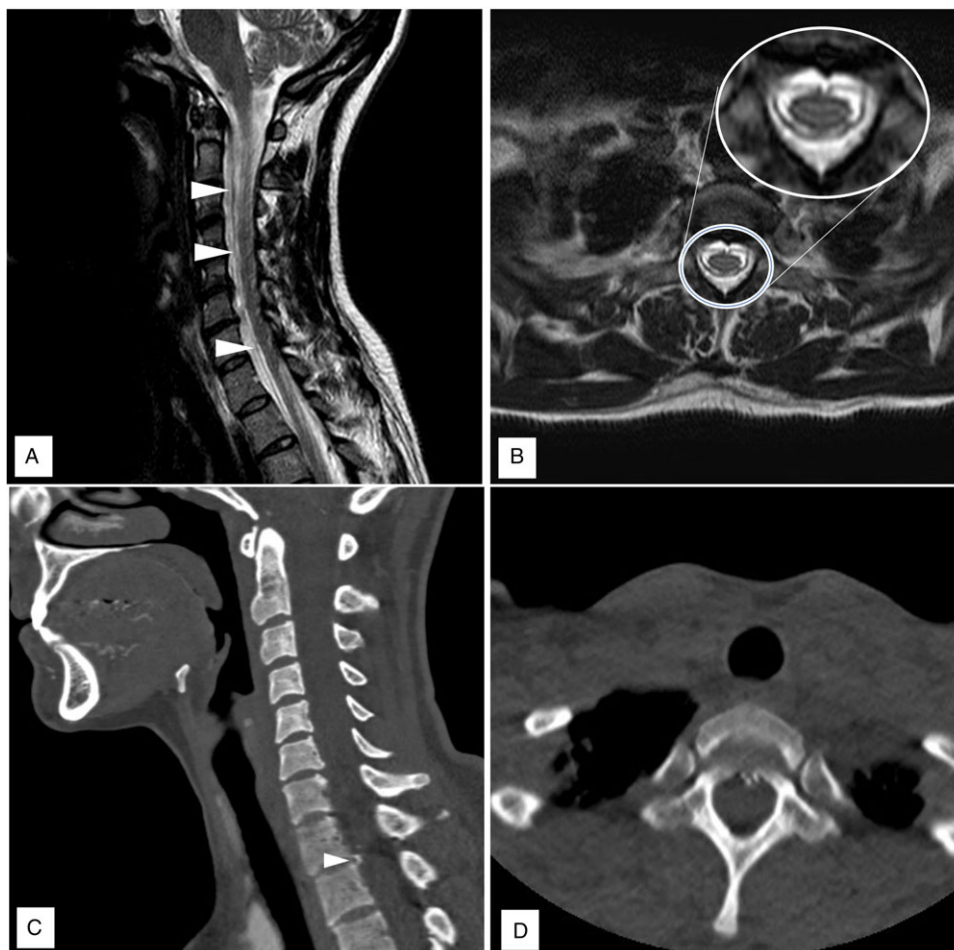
(A) Sagittal T2-weighted MRI sequences of the cervicothoracic spine revealing CSF extravasation within the anterior epidural space (arrowheads). (B) Axial T2-weighted images showing a very focal triangular T1–T2 disc herniation located on the midline and a similarly shaped triangular dural slit. The shape of the dural opening seems to be molded by the disc herniation. (C, D) Cervical (C) and axial (D) CT scan demonstrating the small focus of calcification just dorsal to the T1–T2 disc space, which corresponds precisely to the location of the disc herniation on axial MRI.
